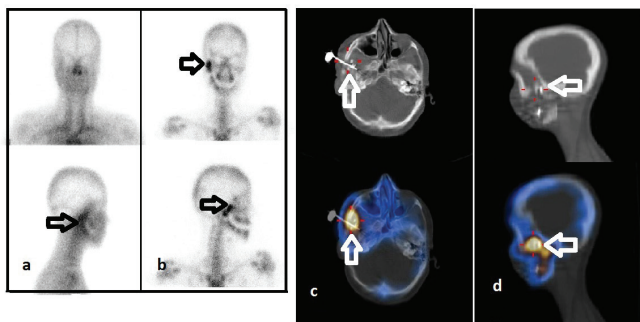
A 18-year-old woman who was operated due to hemifacial atrophy and was being suspected as having osteomyelitis in right mandibula five months after the operation. (A) There is mild hyperemia on the right temporomandibular region in blood pool (B) delayed anterior and right lateral static images show intense focal increased radiotracer uptake in the same area with hyperemia (arrows). (C) Axial and (D) sagittal single photon emission computed tomography/computed tomography, images show intense focal increased radiotracer uptake around the metal implant on the zygomatic bone (arrows). These findings are interpreted as acute osteomyelitis. The result of microbiological examination is reported as infection
